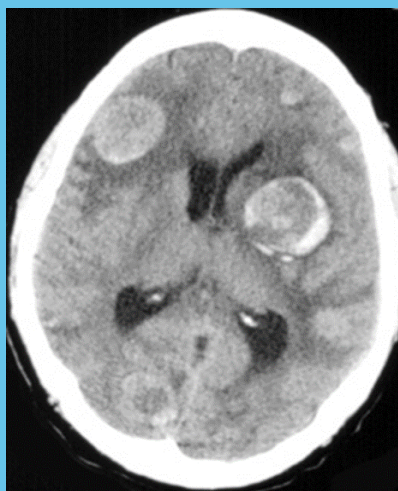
Non-contrast head CT shows multiple dense/hemorrhagic parenchymal metastatic lesions.
